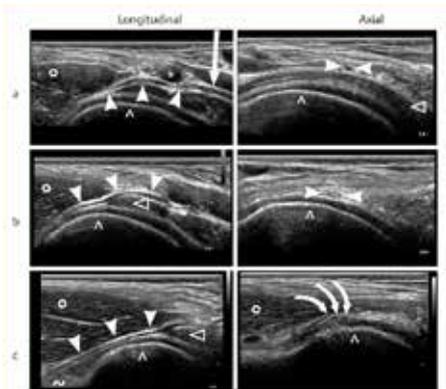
The 2 US scans a (longitudinal and axial) show the sonographic situation at the “leaving” of the AN from the plexus. The 2 US scans b (longitudinal and axial) show the sonographic situation at the “middle segment” and the 2 US scans c (longitudinal and axial) show the sonographic situation at the “distal segment”. The white arrowheads indicate the AN, the white arrow indicates the posterior fascicle of the plexus, (*) indicates the axillary artery, (^) indicate the cortex of the humeral head, (Δ) indicate the subscapular muscle, the rings (o) indicate the teres minor muscle, (~) indicates the long head of the triceps muscle and the 3 bowed, white arrows indicate the 3 terminal branches of the AN forming within the axillary gap.
